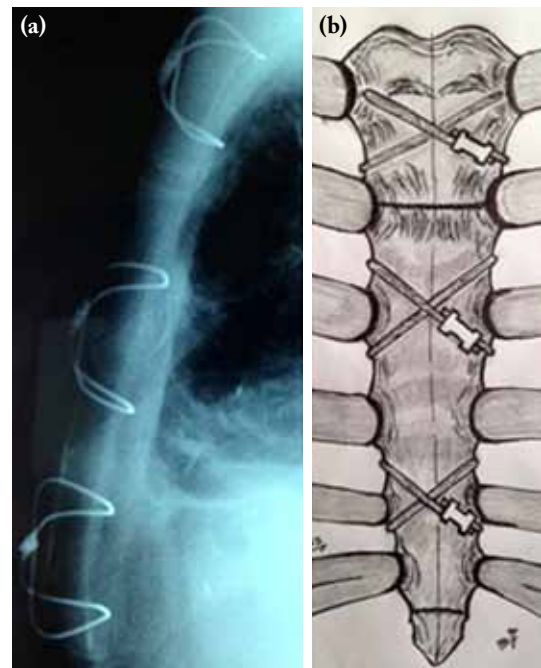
Figure-of-8 suturing (a) X-ray image. (b) Figure-of-8 which made by crossing intercostal spaces.
